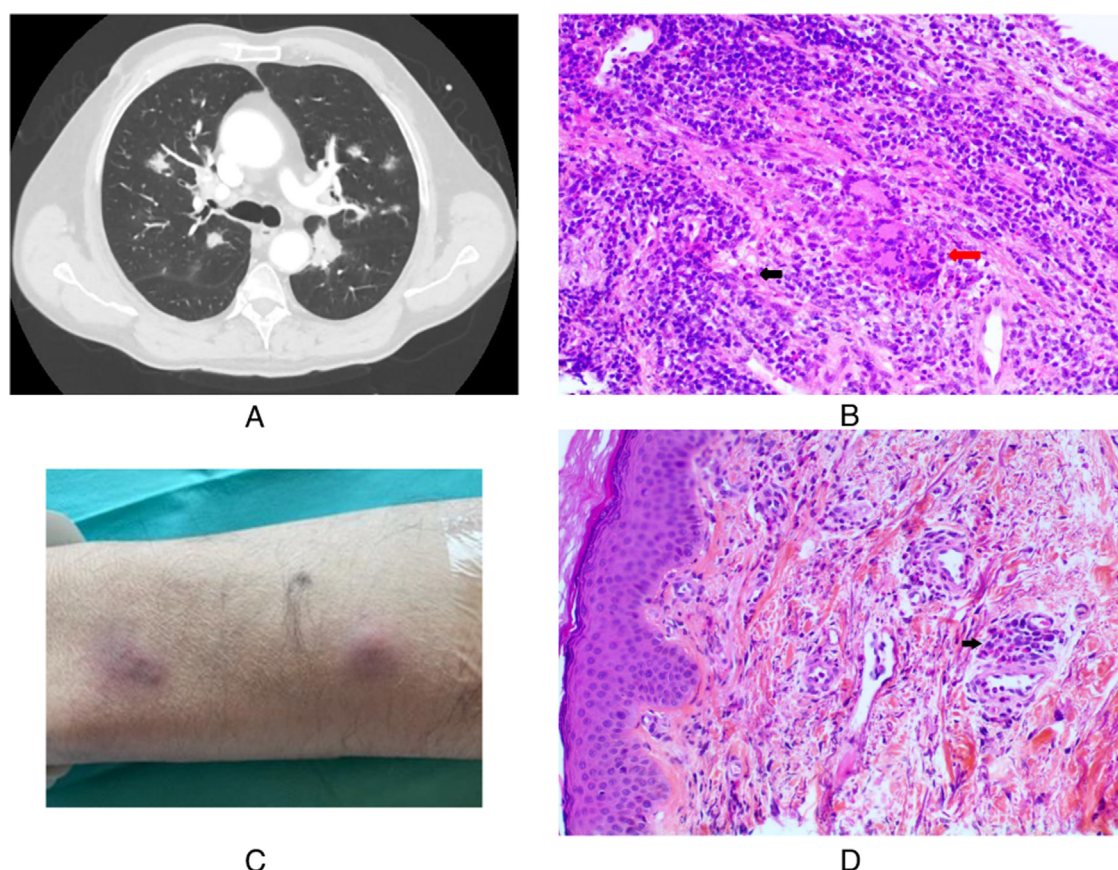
A. Chest CT-scan (axial section): diffuse lung consolidations and ground glass images, B. Bronchial biopsy: granulomatous inflammation with giant and epithelioid cells (red arrow), eosinophils (black arrow), lymphocytes, plasma cells (HES, x400), C. Photograph of the skin lesions (right forearm), D. Skin biopsy: eosinophilic angitis in the superficial dermis. Black arrow: eosinophils. (HES, x200).
